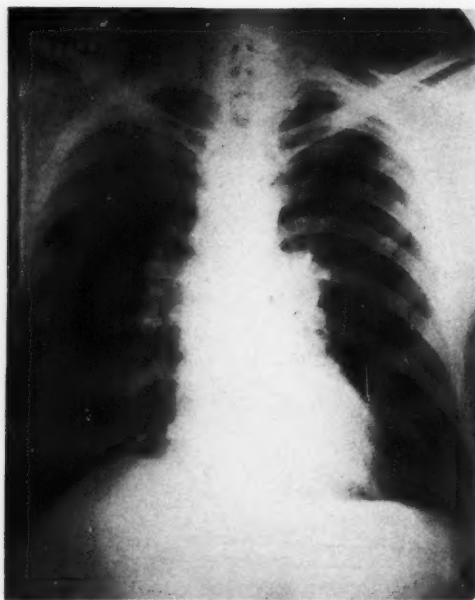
Case 3: Dissemination of lesions through right lung. Roentgenogram made a year and ten months after Fig. 4-A.
